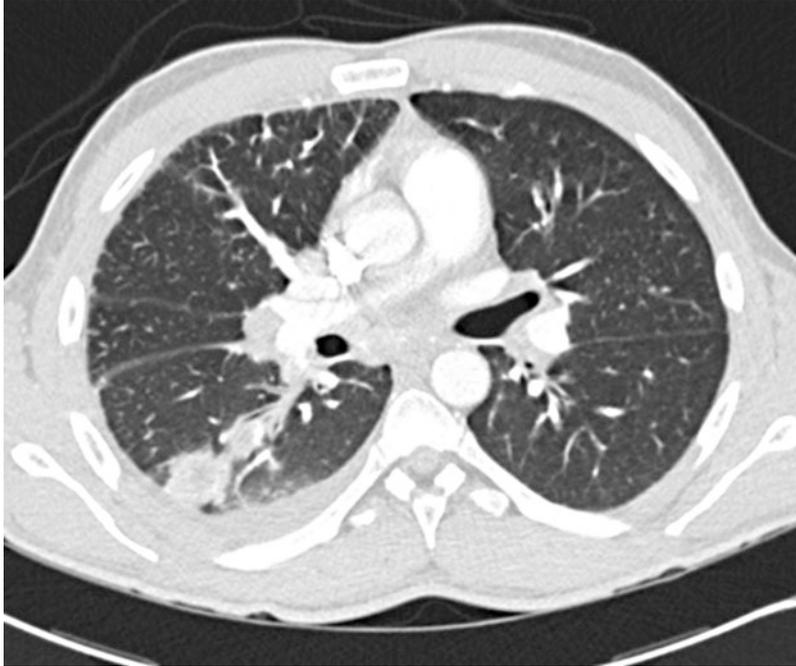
Representative image of the CT chest upon admission
